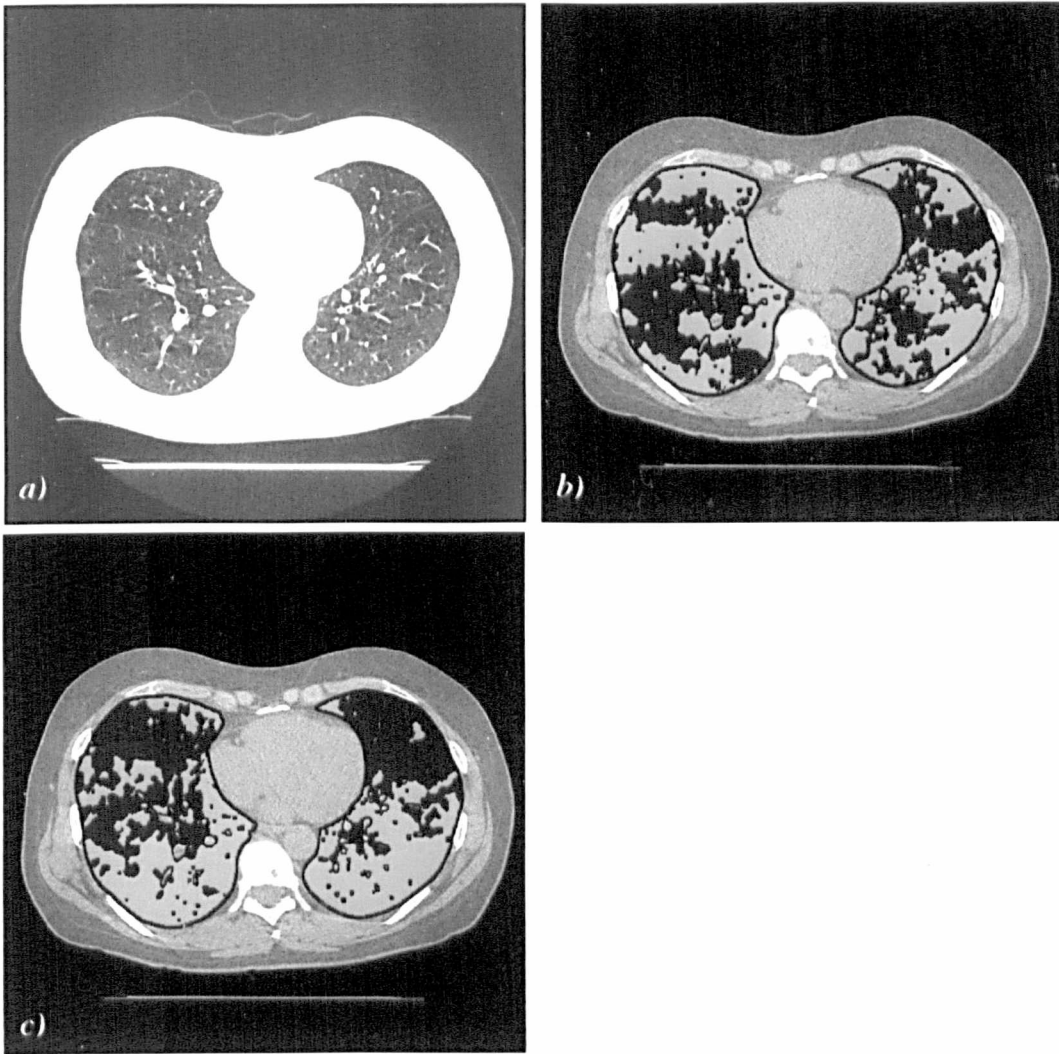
The effect of gradient-correction on the result of classification. *a)* Original CT scan. The anterior part of the parenchyma appears darker because of gravity effect. *b)* Segmented image after gradient-correction. The correct hypo-attenuated areas are identified (shown as the darkest grey shade). *c)* Segmented image without gradient-correction. The areas labelled as hypo-attenuated include most of the anterior lung.
